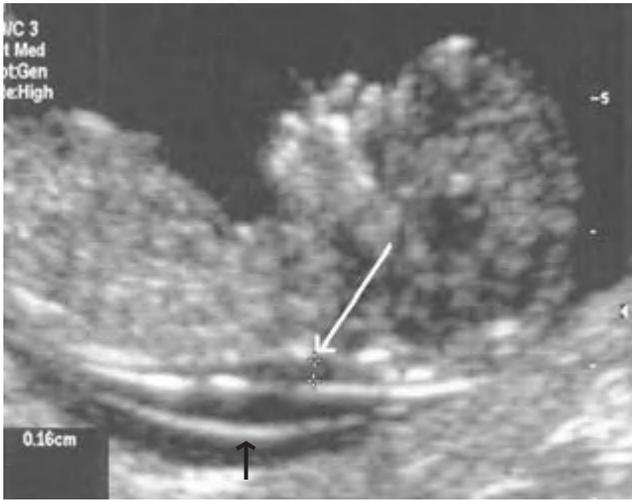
Nuchal translucency (NT) ultrasound measurement at 13 weeks in a chromosomally normal fetus, measuring 1.6 mm. Various features of good NT ultrasound technique are evident in this image: adequate image magnification, mid-sagittal plane, neutral neck position, inner to inner caliper placement perpendicular to the fetal body axis (as indicated by white arrow), and separate visualization of the overlying fetal skin and amnion (black arrow). (From Malone and D'Alton, 2003.)
